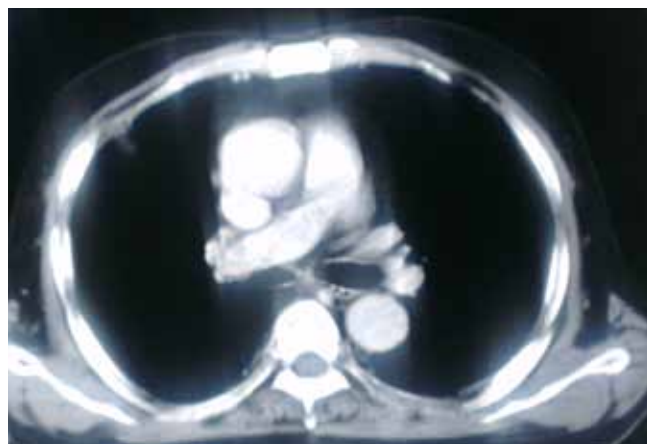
CT scan thorax in October 2013 - Near total remission of the mass.
